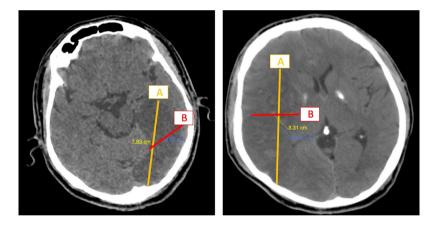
Depiction of the method used to calculate infarct volume on axial computed tomography (CT) images. The measurement is performed by applying the commonly used formula $(A\times B\times C)/2(A \times B\times C)/2(A \times B\times C)/2$, where dimension A represents the greatest diameter of the lesion, B is the diameter perpendicular to A, and C corresponds to the vertical extent of the infarct across the involved slices. This formula provides a practical approximation of the total infarct volume, allowing clinicians and researchers to quantify the burden of ischaemic injury in a reproducible manner.
